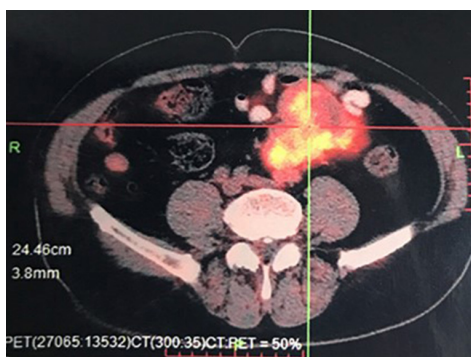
术前PET-CT示左中下腹肠系膜上一分叶状软组织肿块
